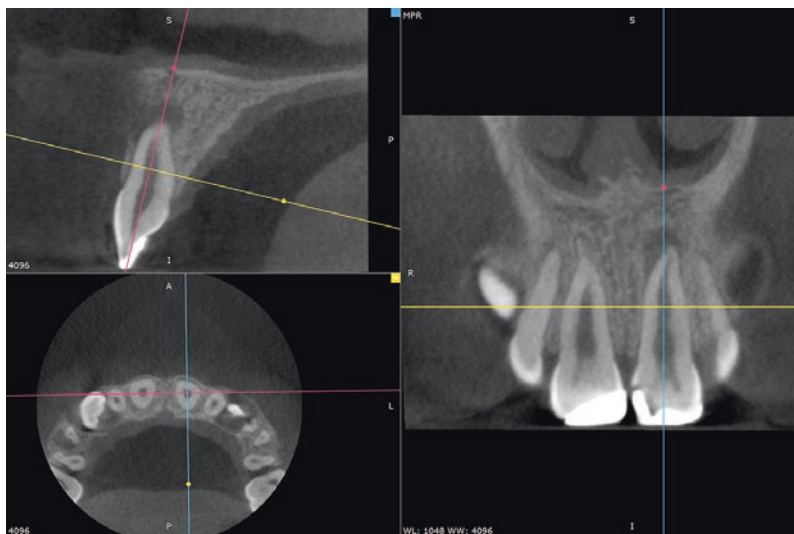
This is a case of trauma to both permanent central maxillary incisors. They were restored previously but clinically the left-hand-side central incisor showed a buccal fistula at the level of its apex. A periapical radiograph cannot show the true extent of the inflammatory lesion and as such a small-field-of-view cone beam CT was made, which showed clearly the three-dimensional characteristics of this lesion. Destruction of the buccal cortical plate is evident. Note that the slices shown in this image are carefully chosen and follow the long axis of the tooth. This is necessary to avoid misinterpretation of the length of the tooth (courtesy of Dr. Stephane Diaz, France)
